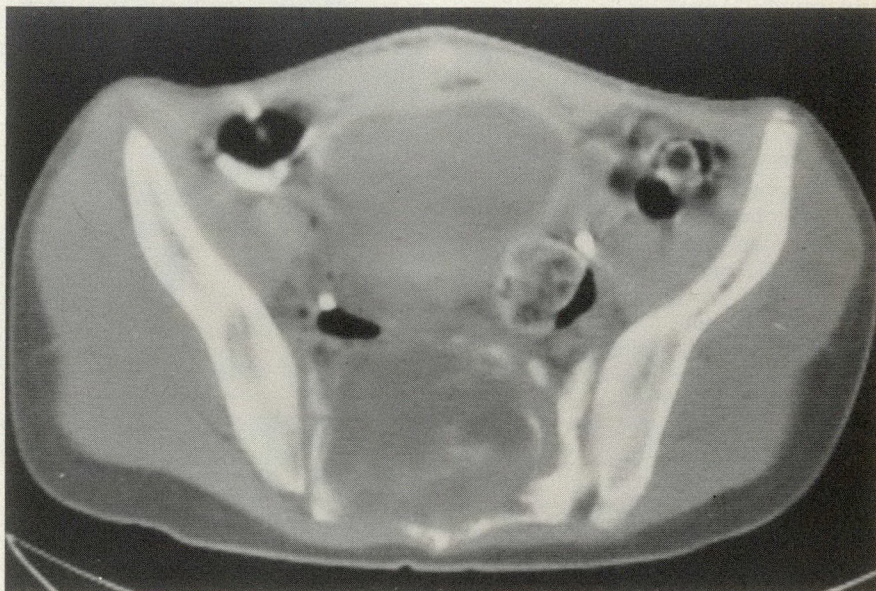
Computed tomogram of pelvis through sacroiliac joints at time of initial presentation shows large sacral tumour causing cortical expansion and destruction. There is inhomogeneity of soft-tissue component, likely due to tumour necrosis and cyst change.
